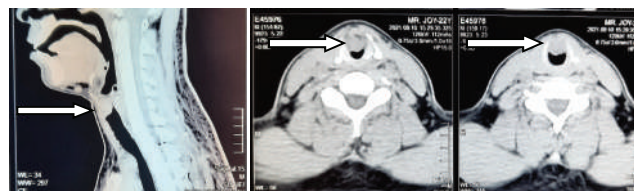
Contrast CT neck showing a moderate homogeneously enhancing well circumscribed soft tissue density lesion (white arrow) measuring about (18 x 20 mm) in subglottic region beneath the anterior commissure
